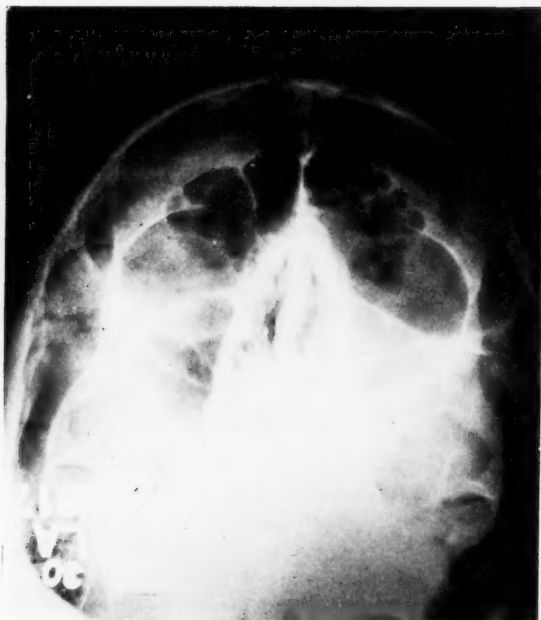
Roentgenogram showing cloudiness of the right ethmoid and maxillary sinuses.
